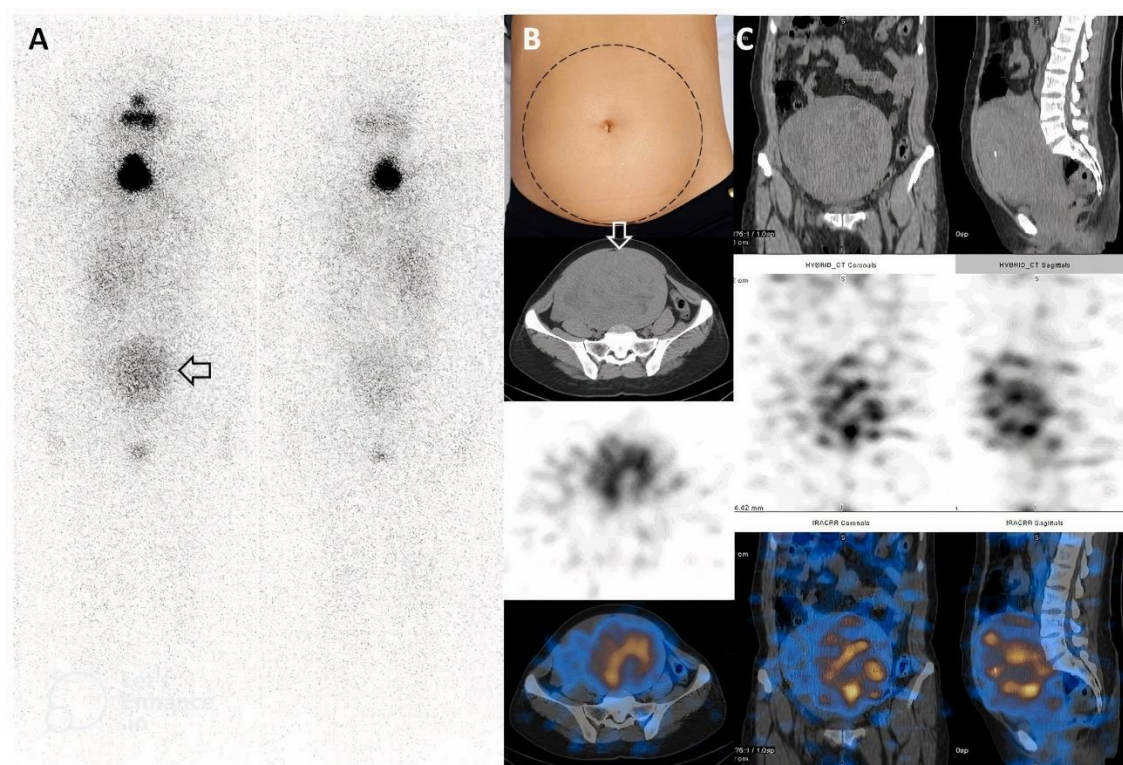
(A) A zone of iodine uptake in the mid abdomen is seen just above the rectum and bladder (arrow). (B) A palpable mass was detected in the lower abdomen on the physical exam (dashed circle). (C) The SPECT/CT images confined the zone of iodine uptake on the WBIS to a large uterine fibroid with smooth peripheral contours and relatively homogenous soft tissue density (arrow). It shows peripheral rim-like FDG uptake and central photopenia, likely suggesting central necrosis. There is enlargement of the right atrium and small pericardial and pleural effusions
